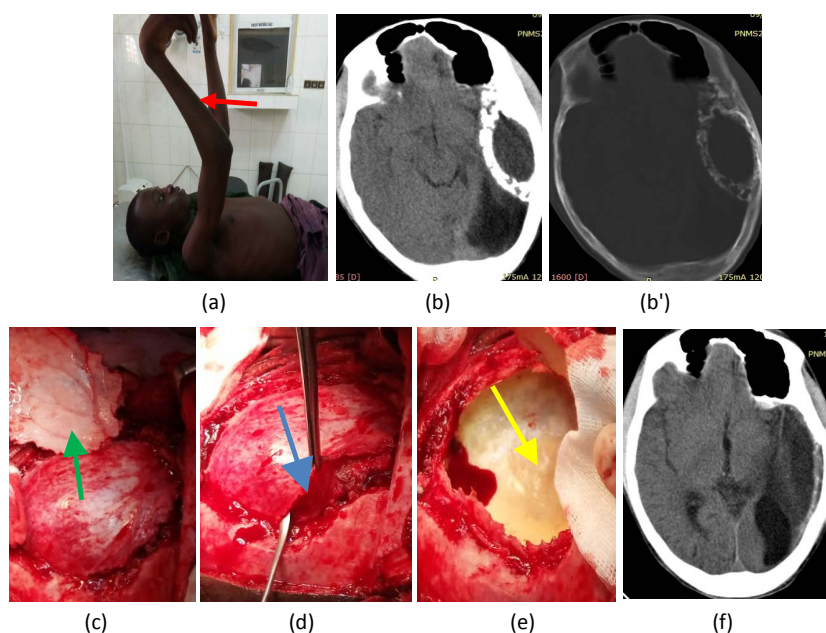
Clinical view of hemi amyotrophic right side (a); pre operative brain CT scan showing a temporo parietal hyper dense mass (b) with on bone window an ossified subdural chronic hematoma (b'). intra operative view showing craniotomy bone flap (c) (green arrow), dura thinner dura mater (d) (blue arrow) and ossified rim of OSCH (e) (yellow arrow). Post operative brain CT scan showing total removal of the mass.
